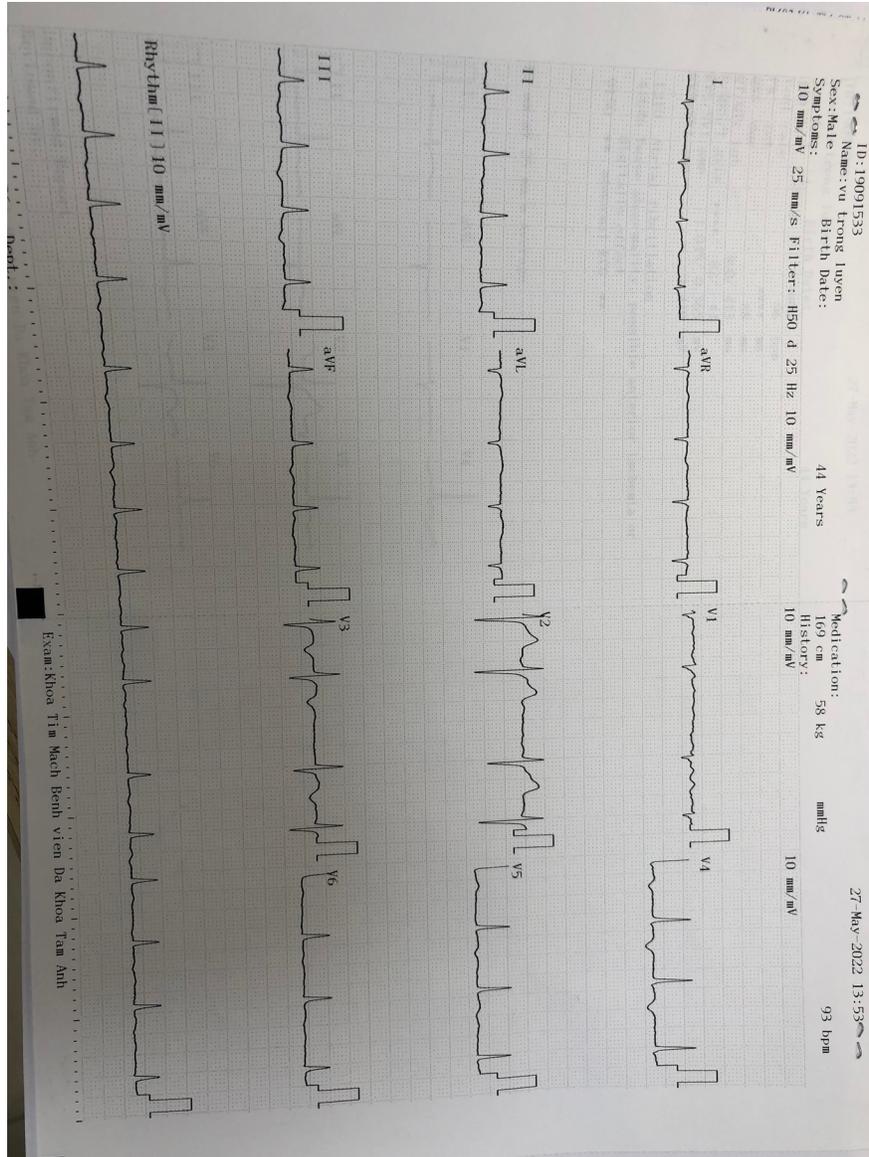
Echocardiogram showed atrial fibrillation
